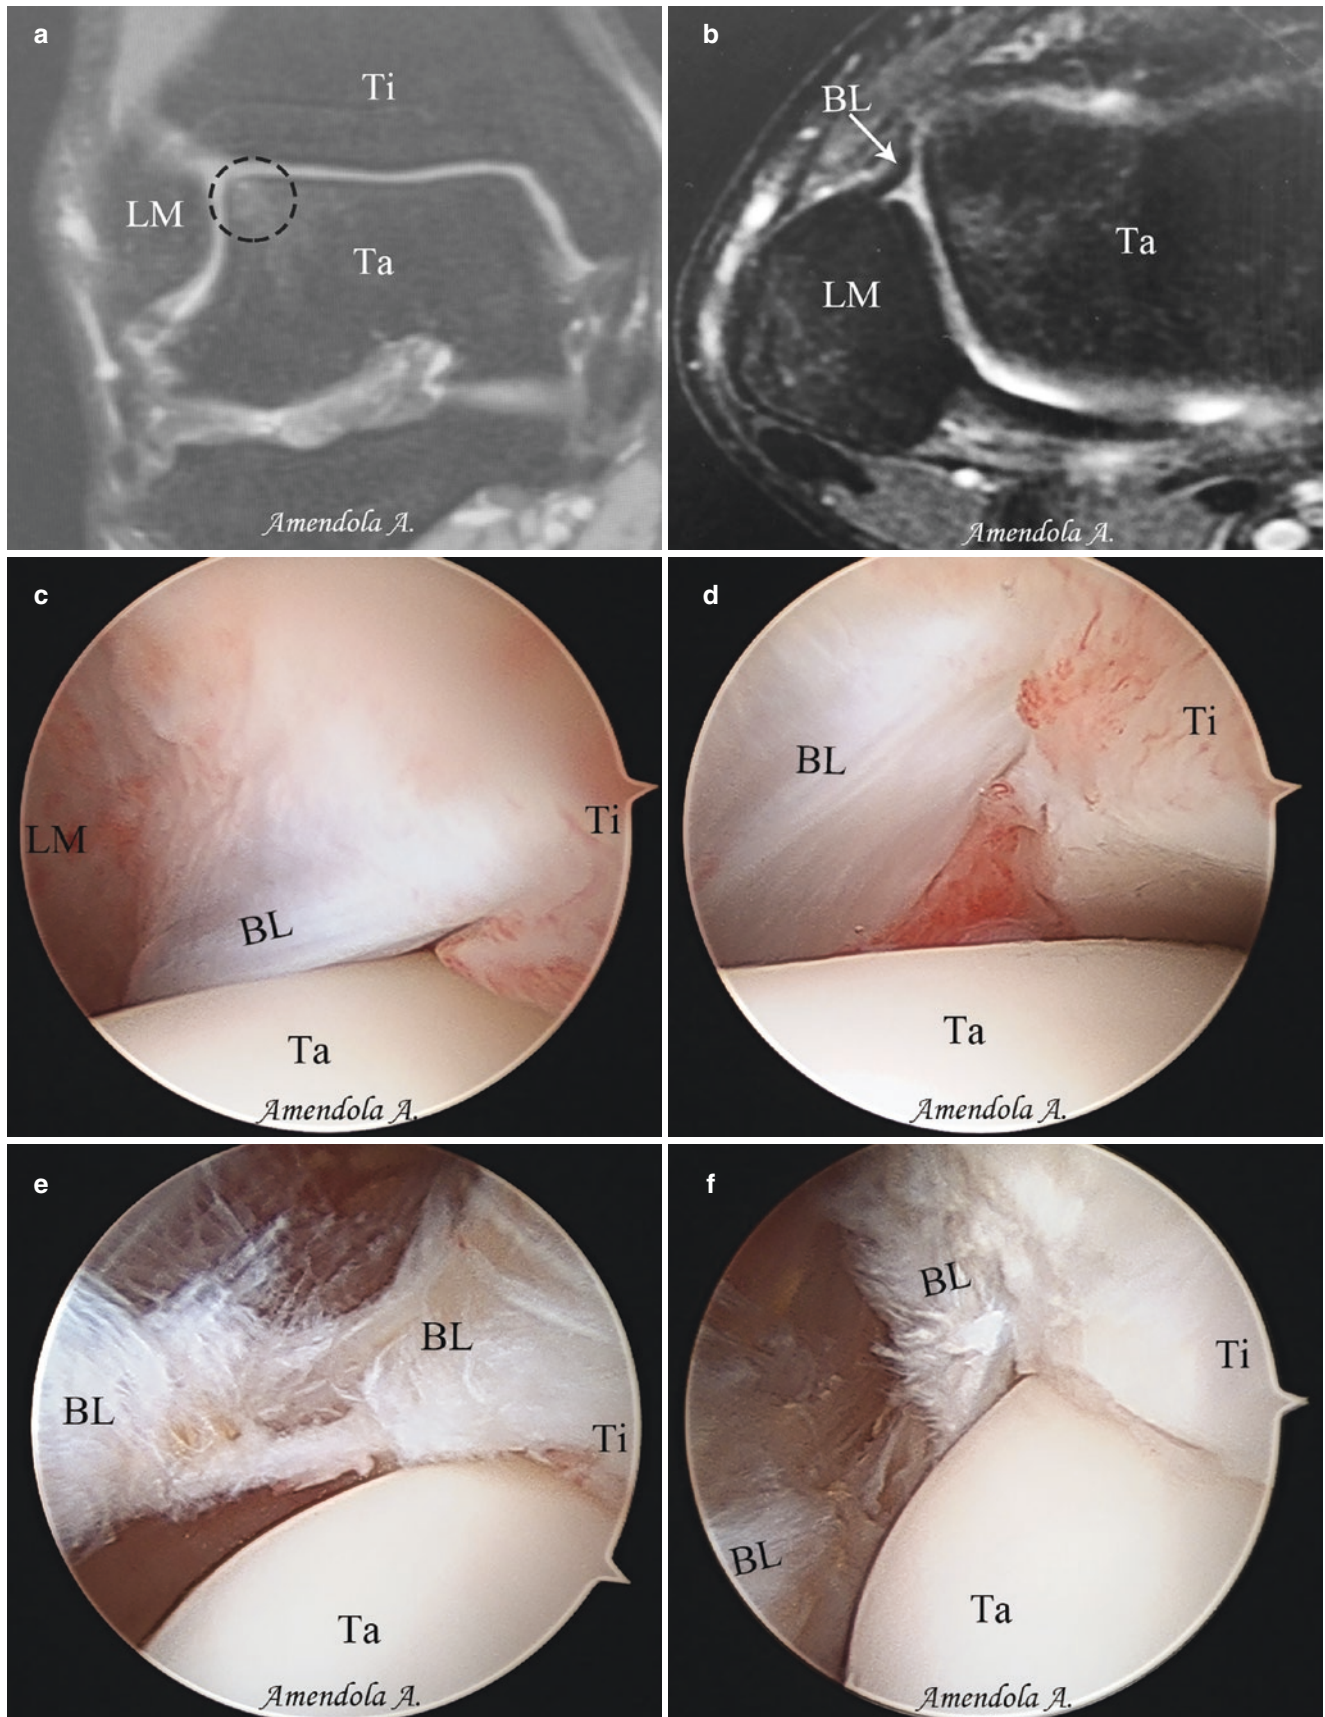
The Bassett's ligament impingement. (a) MRI T2WI, coronal view, the black circle shows the edema of the lateral talar dome. (b) MRI T2WI, axial view, the thickened Bassett's ligament. (c, d)
